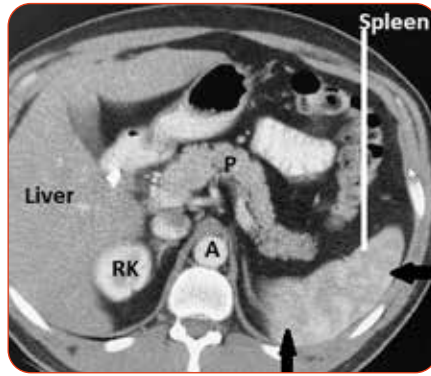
Enhanced axial CT scan showing the spleen lying in the space of the left kidney. Black arrows show areas of hypo and hyper-density in the spleen and are termed 'zebra' spleen. This is a normal finding that is caused by variable flow rates of contrast filled blood through the spleen.^[42] P = pancreas. RK = right kidney. A = aorta.
